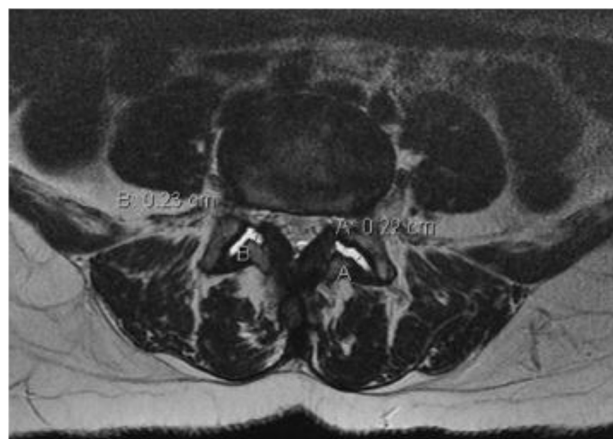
Axial T2 image demonstrating facet fluid measurement method described by Chaput. Measure the maximal distance between the inferior and superior articular process where the effusion signal matches the signal of the cerebrospinal fluid. (Reprinted from Snoddy MC, Sielatycki JA, Sivaganesan A, Engstrom SM, McGirt MJ, Devin CJ. Can facet joint fluid on MRI and dynamic instability be a predictor of improvement in back pain following lumbar fusion for degenerative spondylolisthesis? *European Spine Journal*. 2016;25(8):2408-15) © Springer-Verlag Berlin Heidelberg 2016. With permission of Springer.)
